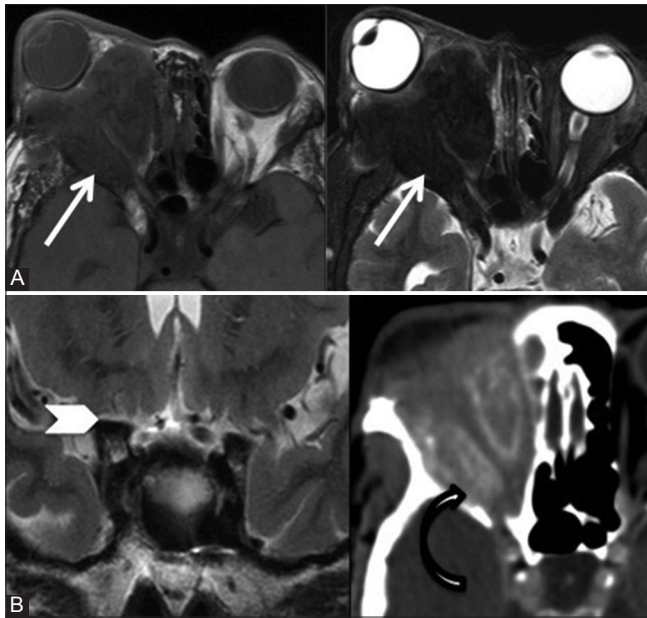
(A and B): Tumors: Optic nerve sheath meningioma: Axial T1 and T2 fat-saturated (A) and coronal T2W and CT scan (B) images of a 59-year-old female with right proptosis since 20 years and progressive loss of vision show T1-isointense and T2-hypointense soft tissue mass surrounding the optic nerve which shows calcification (curved arrow). Also note severe atrophy of prechiasmatic segment of right optic nerve (arrowhead) in the image
